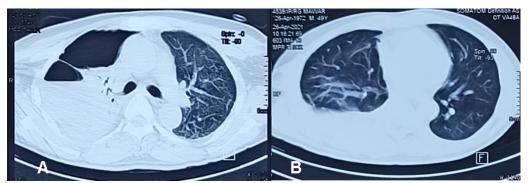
A) Extensive pulmonary fibrosis in the posterior segment of the right inferior lobe, middle lobe, and superior lobe of the right lung. Infected giant bullae in the superior lobe of the right lung which was smaller in size than the previous chest CT scan. Right pneumonia which was reduced in size compared to the previous imaging; B) Post-COVID fibrosis of both lungs with traction bronchiectasis. No bullae and pneumonia were seen. The right lung expansion appeared better than previous CT scan results.
